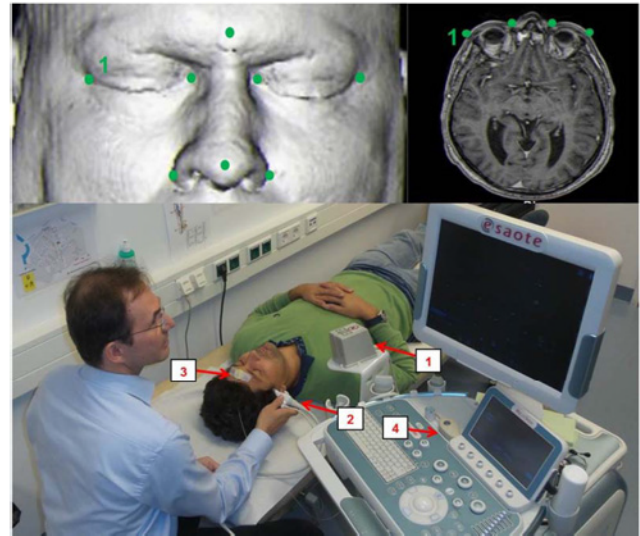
The navigated neurosonography environment.
